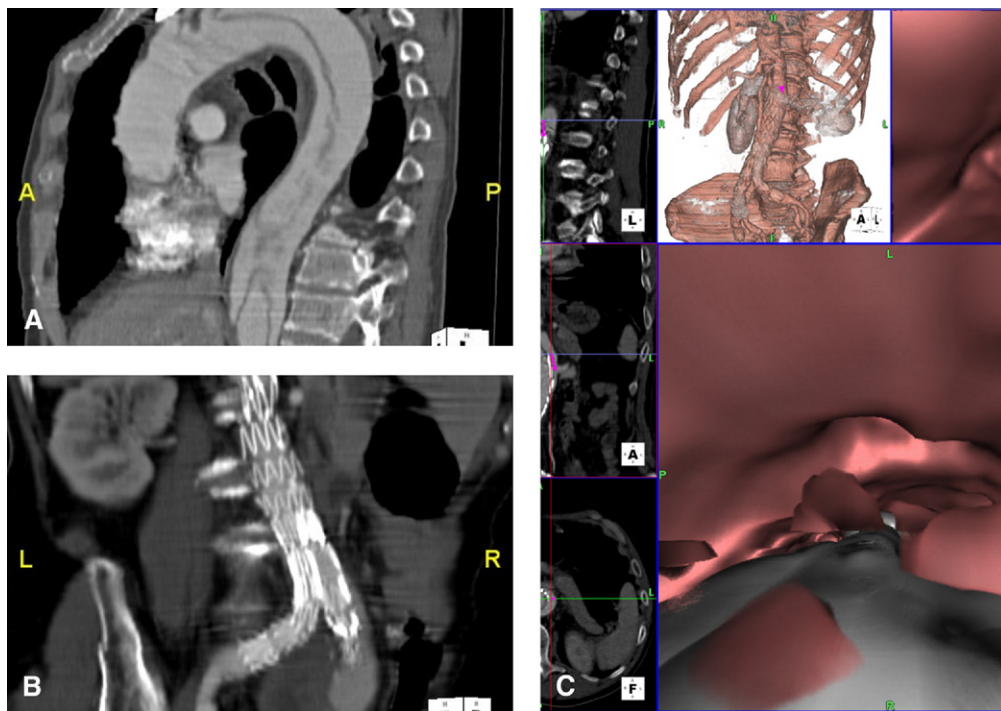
Preoperative computed tomography (CT) scan showing the origin of the dissection (A), the extension to the right iliac artery (B, *posterior view*) and virtual angiography of the aortic dissection with the images of the false lumen at the level of proximal original endograft and the ostium of left renal artery arising from the false lumen (C).
